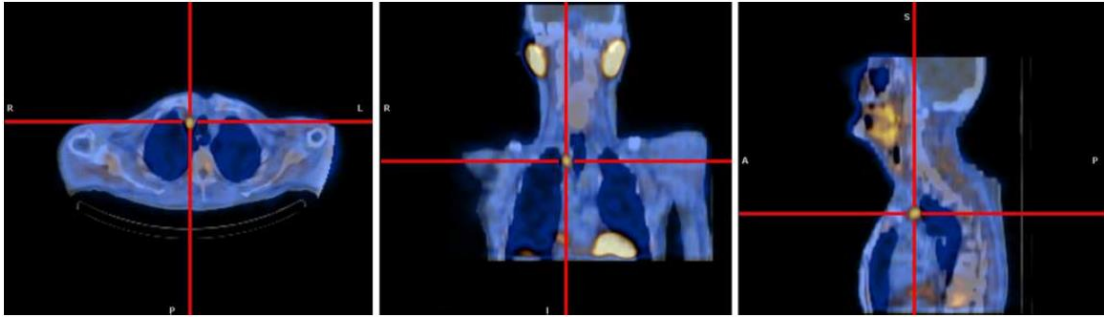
Example SPECT-CT images in a patient with an ectopic parathyroid adenoma in the upper mediastinum, right paratracheal region (as indicated by the centre of the red-cross). The fused anatomical and physiological details provides valuable information to aid surgical procedures [23].
